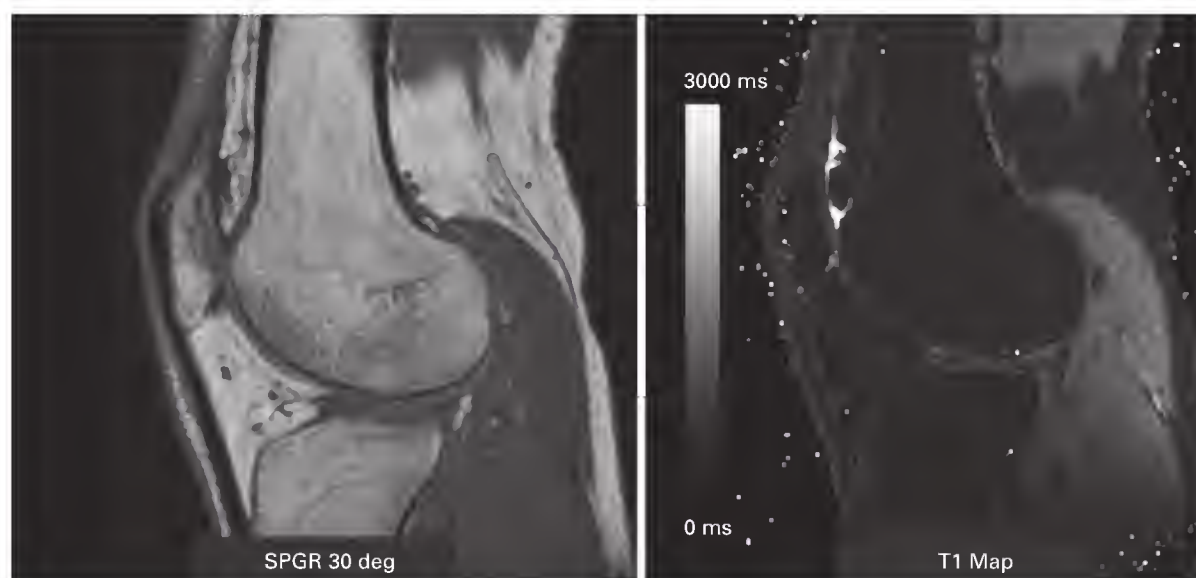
Delayed gadolinium-enhanced magnetic resonance imaging of cartilage in a healthy volunteer. The left image is a spoiled gradient-echo image used to map the T1 relaxation times. The right image is a T1 relaxation time map with a gray scale from 0 to 3000 ms.
